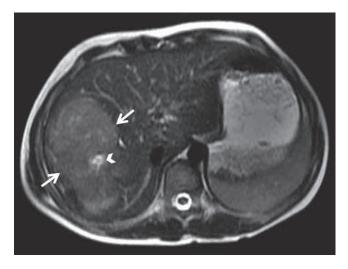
Axial T2-weighted MR image demonstrates a large hyperintense tumor in the right liver lobe (arrows). Note also the cystic-necrotic area in the central part of the tumor (arrowhead).
